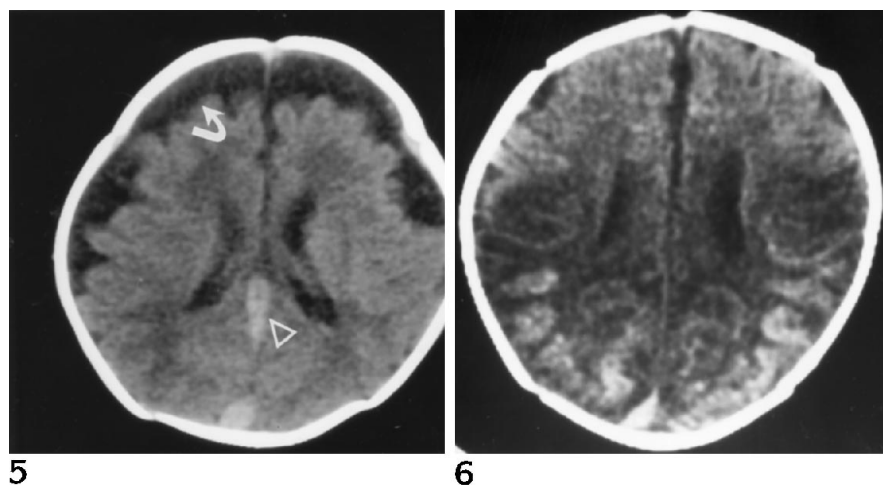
Infant with a congenital diaphragmatic hernia in whom superior vena cava thrombosis developed during ECMO treatment. CT scan at 6 weeks of age shows large bilateral extraaxial fluid collections (arrow). The straight sinus (arrowhead) is dilated, suggestive of venous hypertension.
